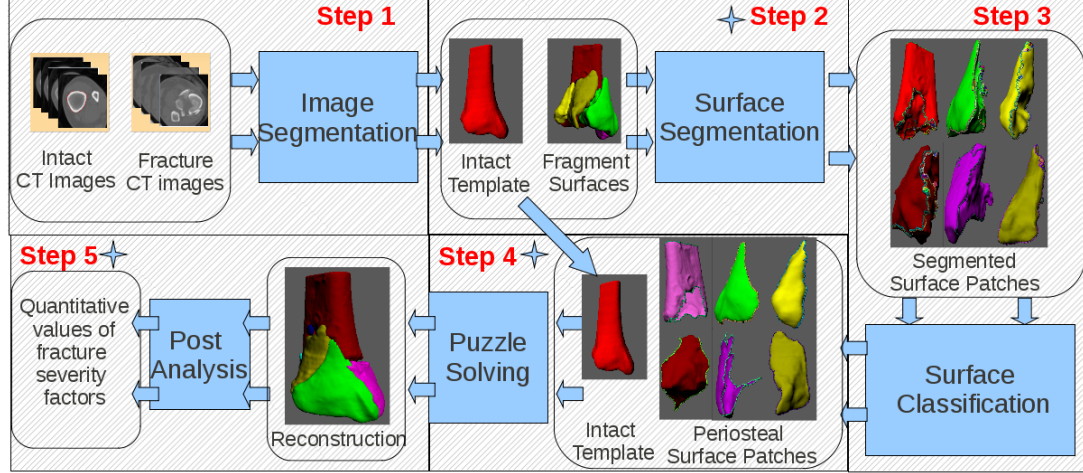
A brief overview of 3D reconstruction system which takes fracture CT images and intact CT images as input and provides a virtual reconstruction of bone fragments which estimates the anatomy of patient’s original bone. Solid color denotes the process by which the data has been changed to allow for a reconstruction to be computed.
